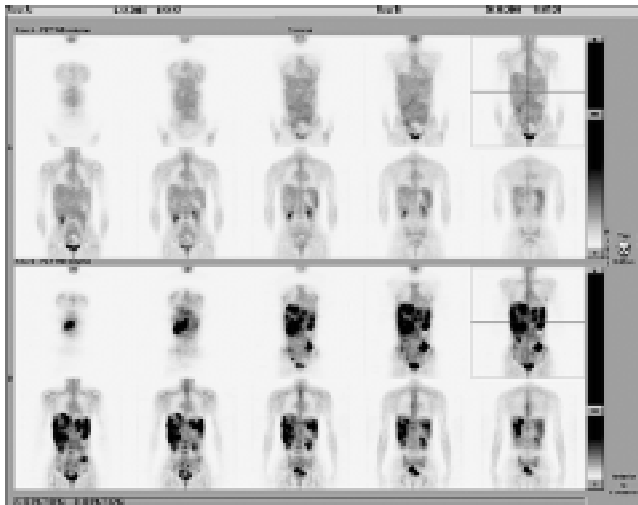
Bottom half of the figure: FDG-PET before therapy detects multiple foci of high tracer uptake in the area of the liver and the abdominal cavity. The finding indicates the presence of viable tumour tissue. Top half of the figure: control FDG-PET after therapy. Perfect clearance of the metabolically active foci indicates a good response to therapy.
